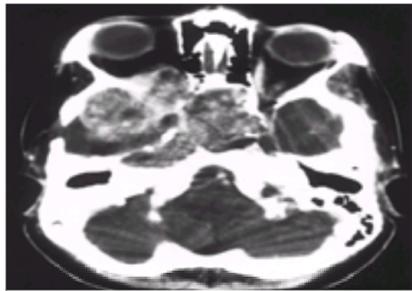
Computed tomography scan of the base of skull of a woman with proptosis and right-sided facial pain. There is extensive tumor erosion of the orbital wall, clivus, and the floor of the middle cranial fossa.
